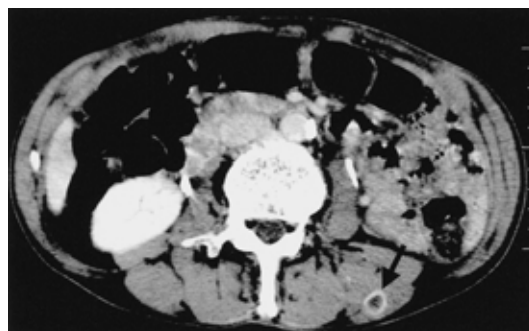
Abdominal CT taken on admission showed a ring enhanced soft-tissue mass (1.5 cm in diameter) in the left lumbar muscle (arrow head)
